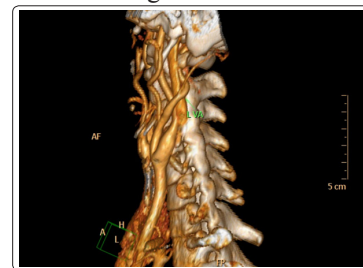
CTA image of left ECA-based left VA
